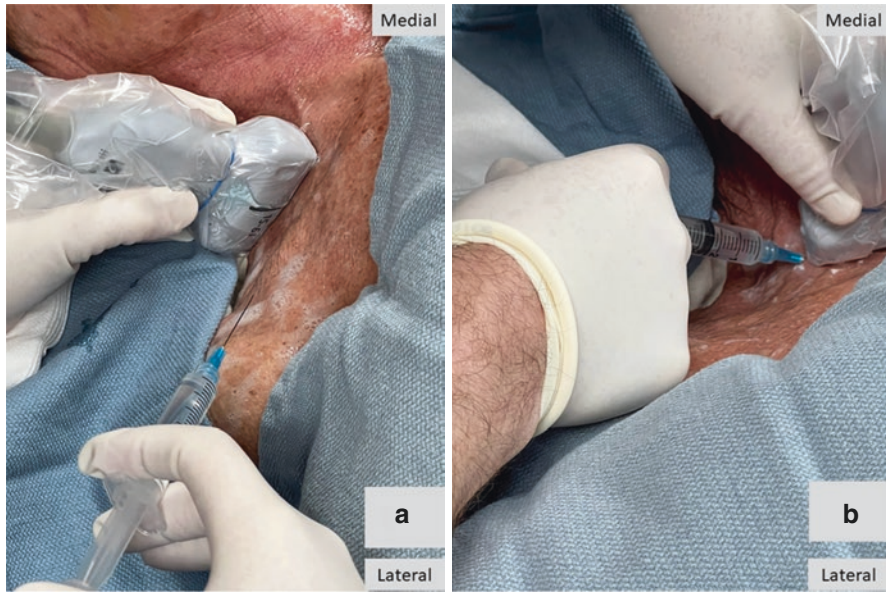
Anterior scalene muscle injection. The patient positioning and ultrasound transducer orientation (a) and needle direction (b) are presented
